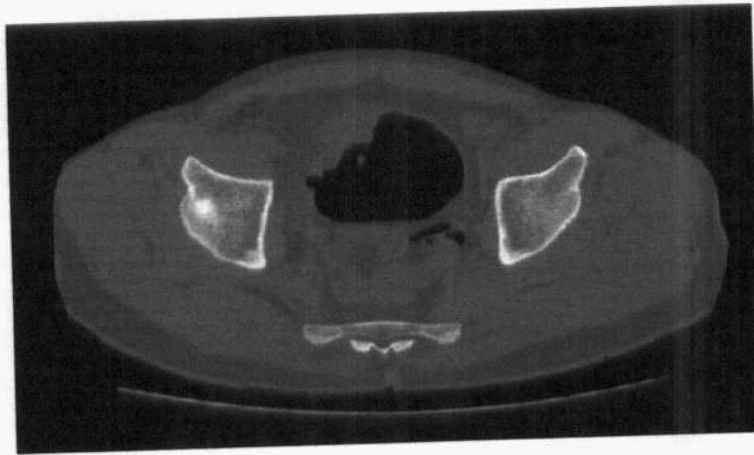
Axial CT with air contrast.
